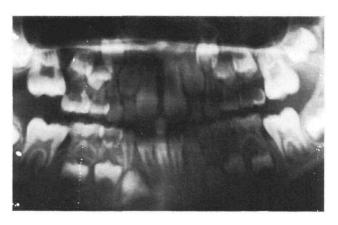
Panoramic radiograph showing premature resorption of maxillary right and left second primary molars.
